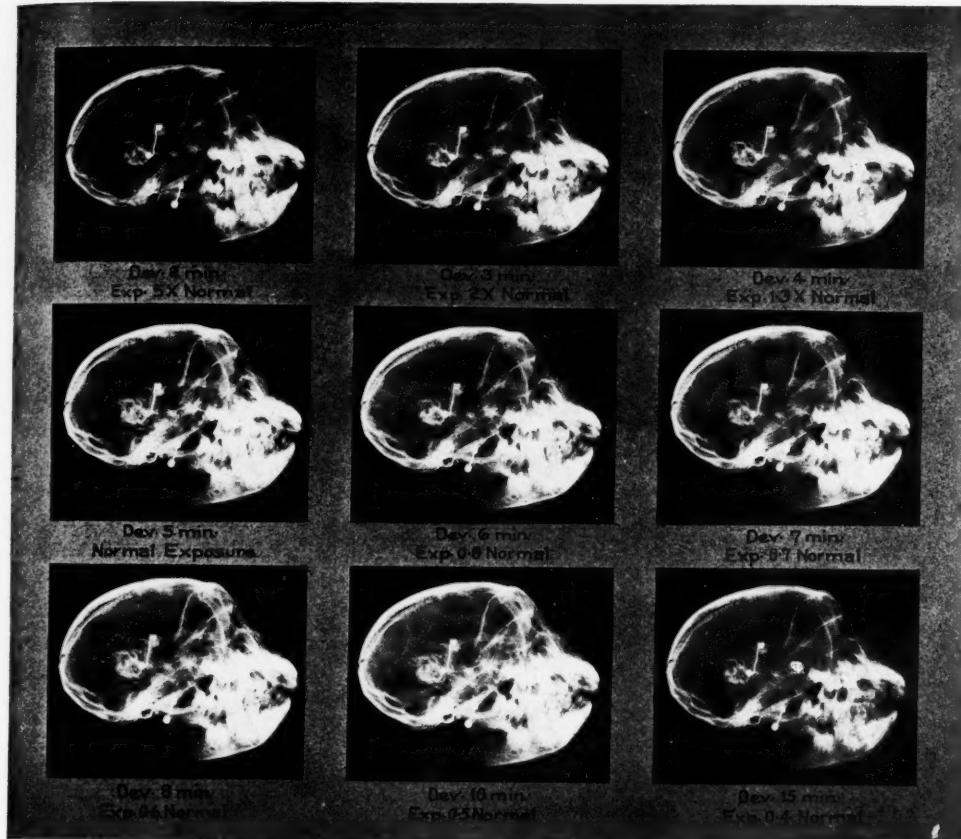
Radiographs of small skull, exposed for various times, and developed to give equal average density of negative. The best radiographs are given in four to eight minutes' development; development times outside this range give inferior quality regardless of exposure. (Owing to the loss of detail in copying these radiographs by the half-tone process, the effect of too short or too long development is not as apparent as in the originals.)
